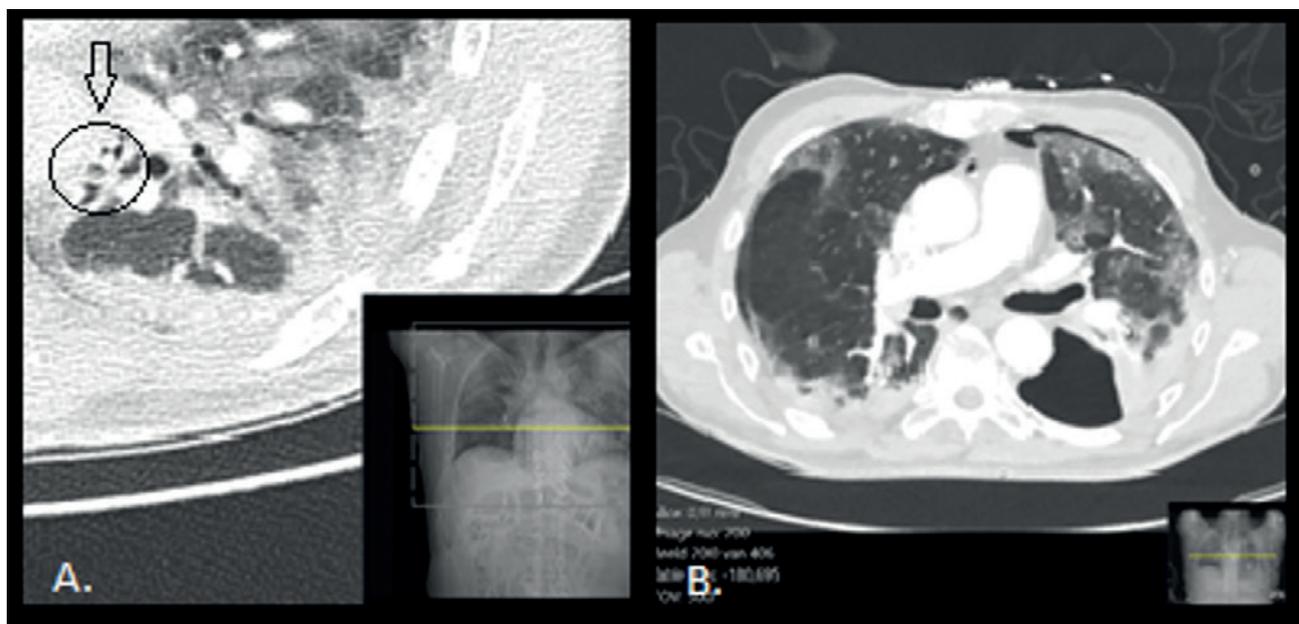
A. CT scan on admission: the Macklin effect. The arrow is pointing towards air next to the bronchovascular bundle (visible within the upper part of the circle)
